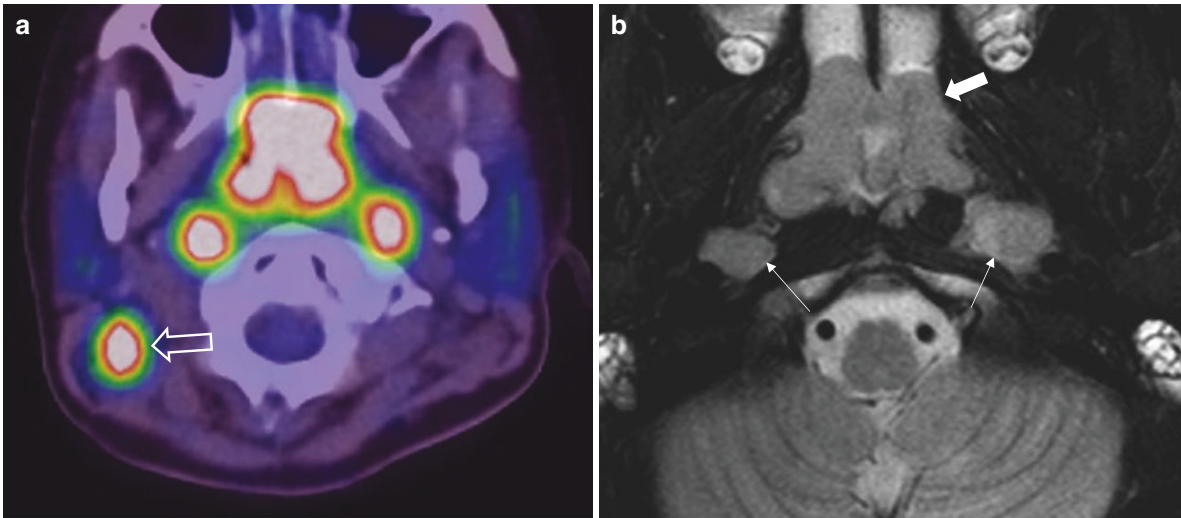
Lymphoid hyperplasia mimicking an NPC. (a) Axial FDG PET/CT and (b) axial T2 fat saturated images showing a bulky nasopharynx (solid arrow) retropharyngeal nodes (thin arrows) and right
